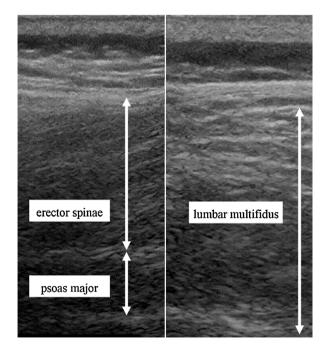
Representative ultrasound images of lumbar back muscles.
